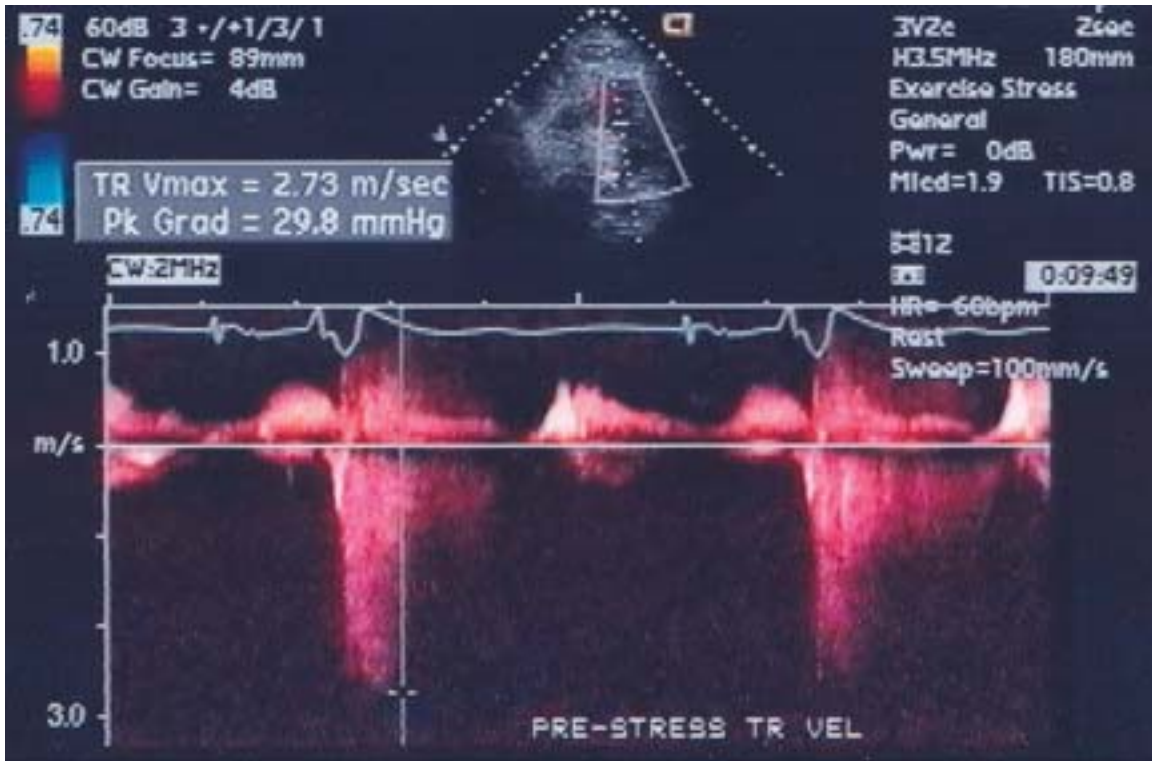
CW Doppler signal of TR velocity at rest, TR vel.= 2.7 m/sec, RVSP = 30 mmHg.
